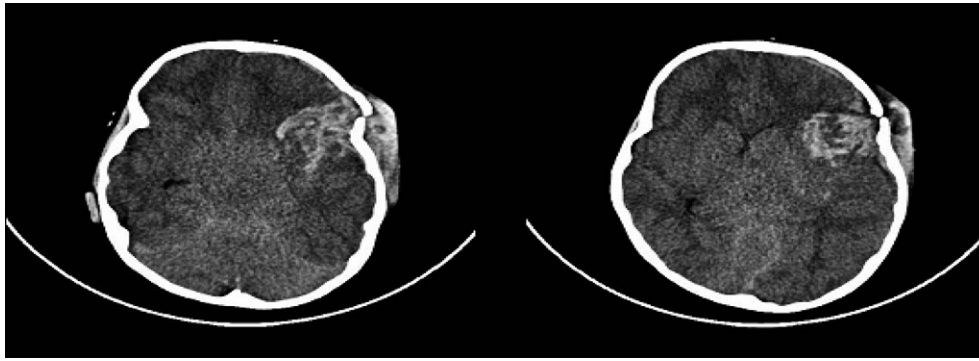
CT scan showing Sylvian region contusion and MCA Territory Hypodensity.
